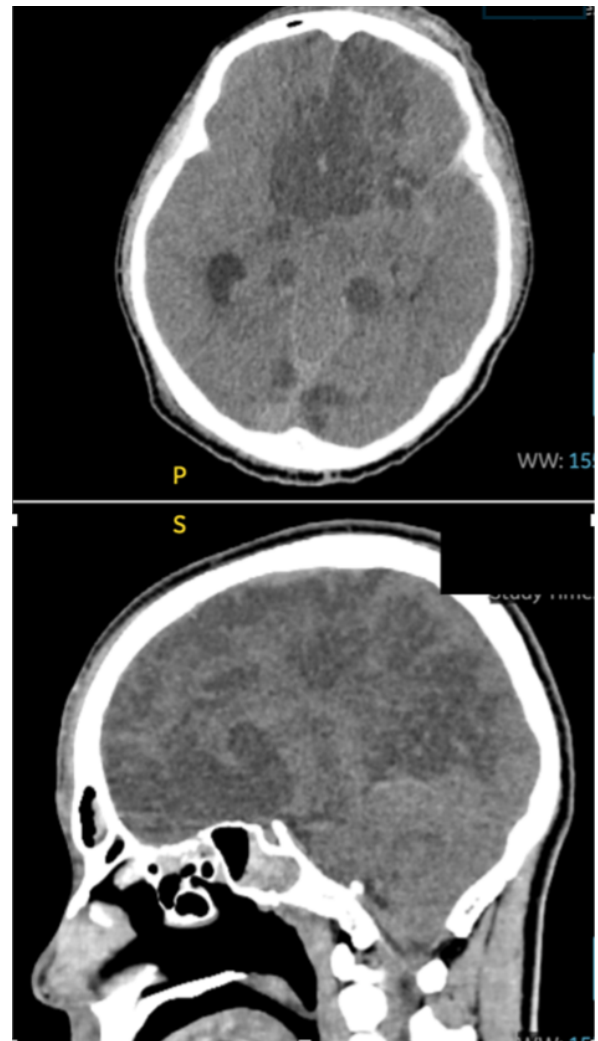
CT demonstrating bilateral parasagittal hypodensities in the ACA territory. This pattern is compatible with A2–A3 segment involvement within the proposed framework, corresponding to medial frontal and callosal infarction (Type C pattern).
